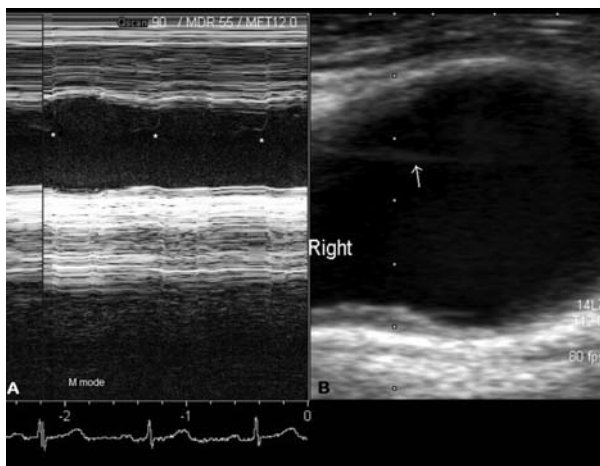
Mobile echo in the carotid bulb. A M-mode imaging of the thin, mobile, intraluminal echogenic structure that is seen emanating from the right carotid bulb in the 2-dimensional ultrasound shown (B) (arrow). Asterisks mark this mobile echo in (A), where it is shown on M-mode imaging to oscillate in and out of the carotid lumen with each cardiac cycle.
